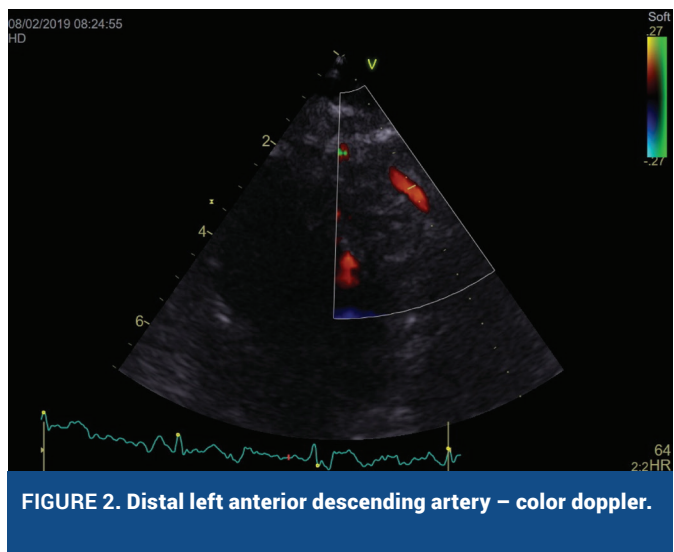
Distal left anterior descending artery – color doppler.
